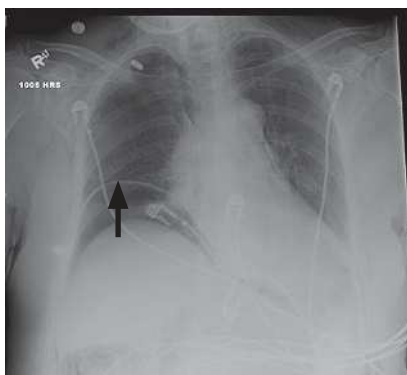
Pneumoperitoneum. Upright chest x-ray (CXR) reveals free air under the diaphragm. (Reproduced with permission from USMLE-Rx.com.)
